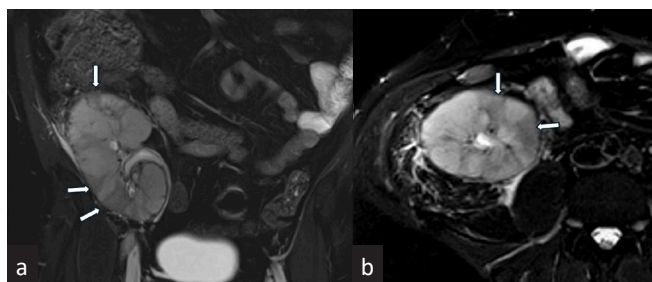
A T2 weighted MRI images of the transplant kidney. (a) Coronal and (b) axial images shows multifocal, wedge-shaped areas of T2 hypointensities (white arrows) suggestive of cortical infarcts.
